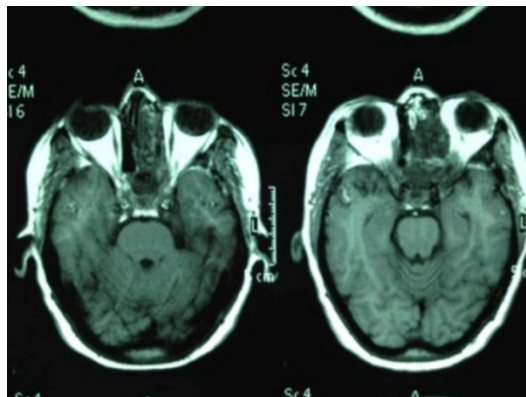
MRI scan showed the expansion of the middle turbinate.
